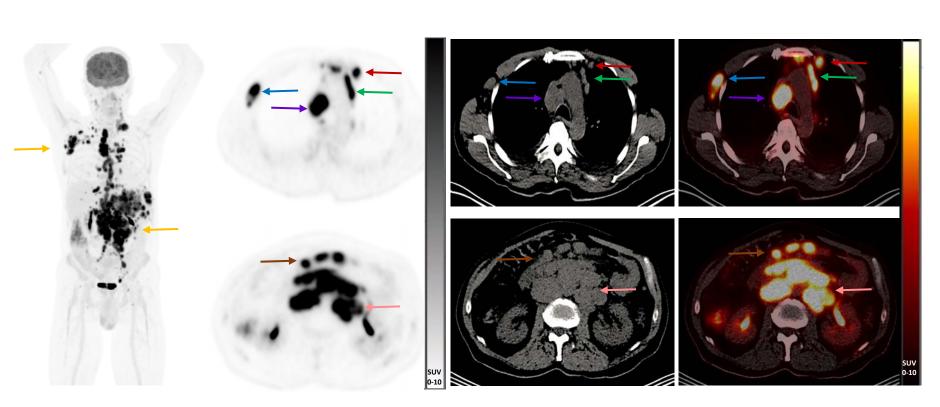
[18F]FDG PET/CT Scan
